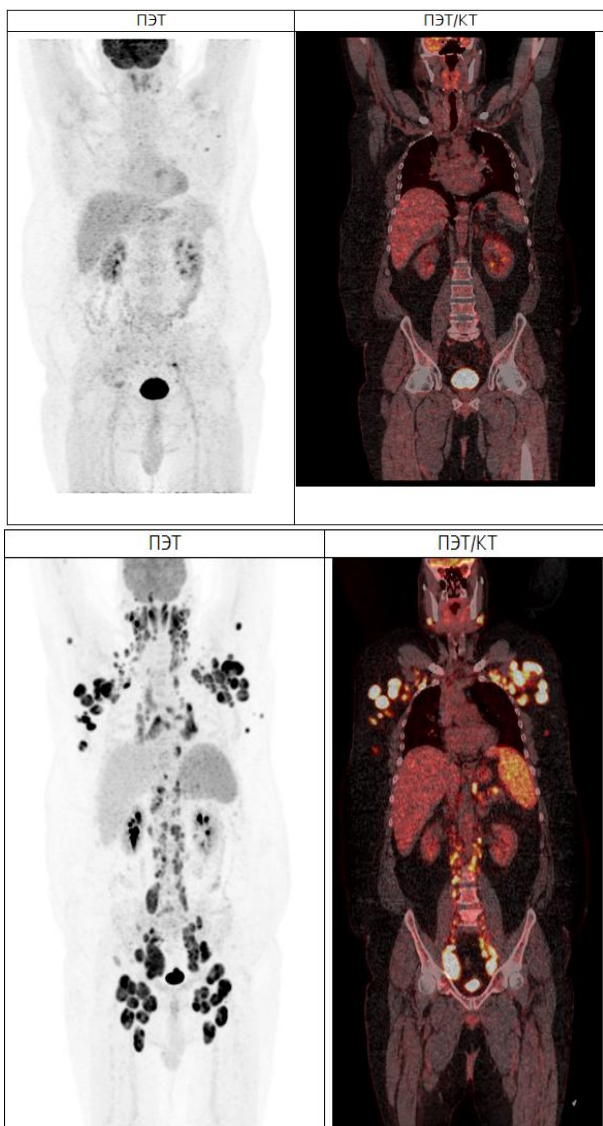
PET/CT image of the patient
